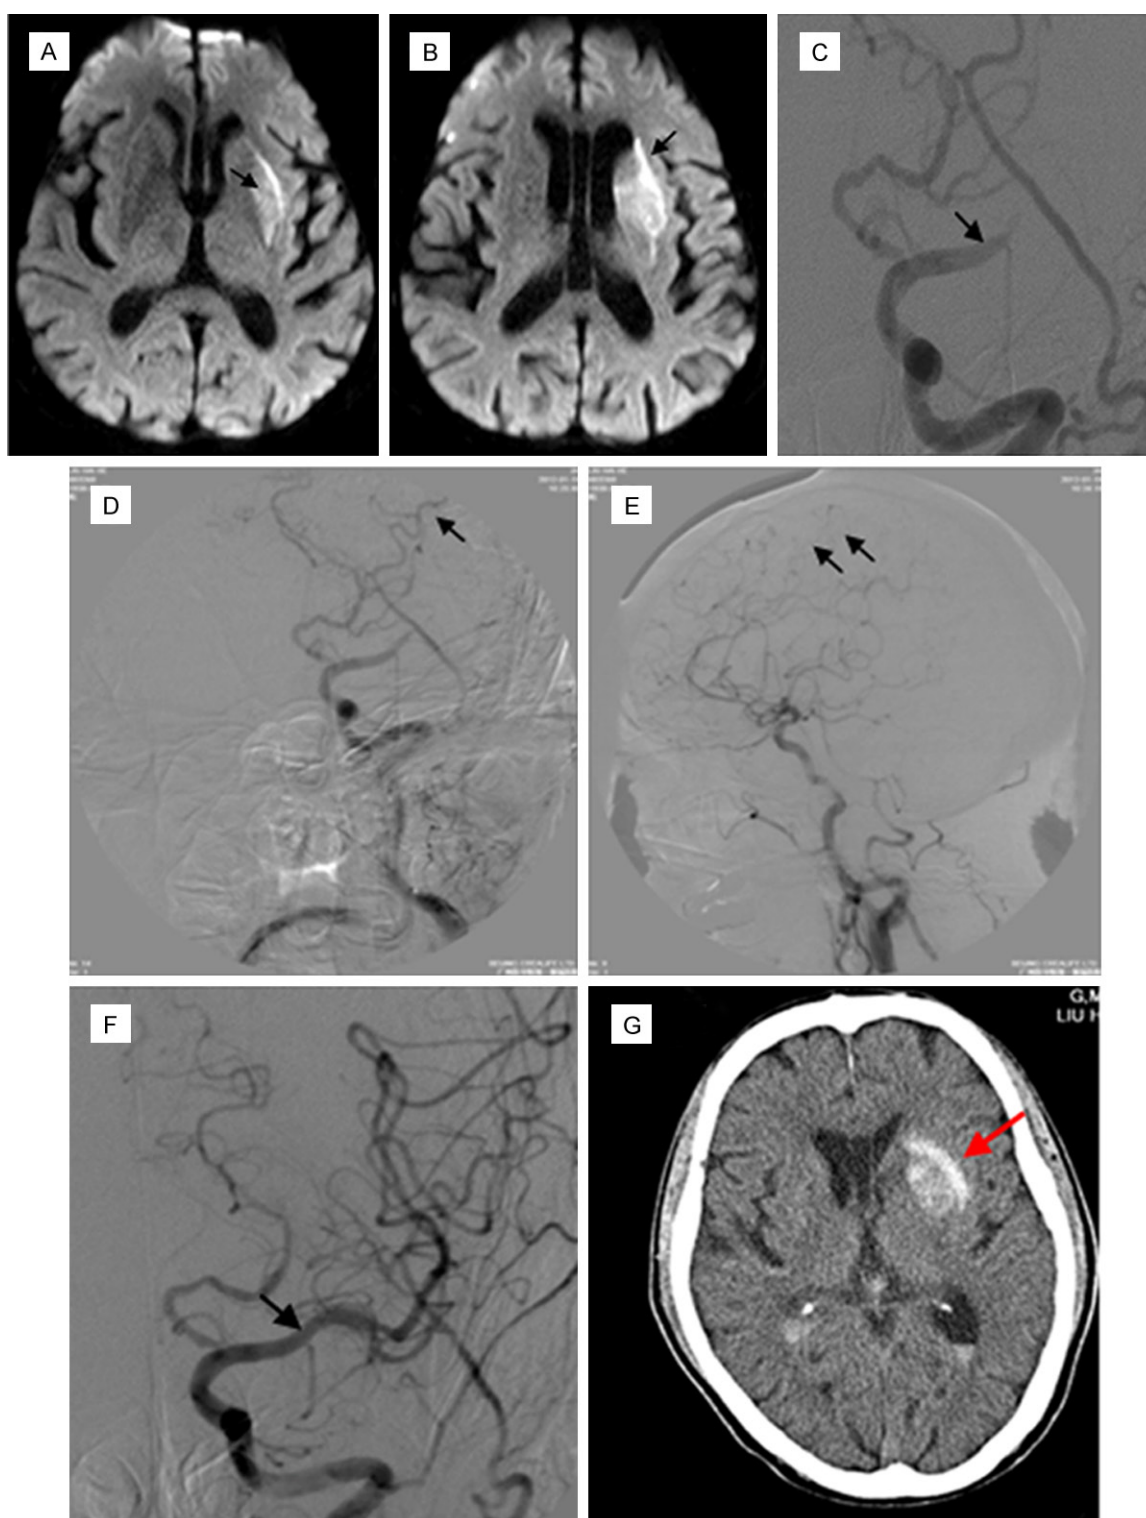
Radiographic and angiographic images of Case 3. (A) DWI showed fresh infarctions in the left basal ganglia area (black arrow). (B) DWI showed fresh infarctions in the corona radiata (black arrow). (C) M1 segment of the left MCA was subtotal occluded (black arrow). Lateral (D) and anterior (E) cerebral angiographic images showed compensatory leptomeningeal arteries from anterior cerebral artery (black arrows). (F) Occluded MCA recanalized (black arrow). (G) Postoperative CT showed asymptomatic basal ganglia hemorrhage (red arrow).
